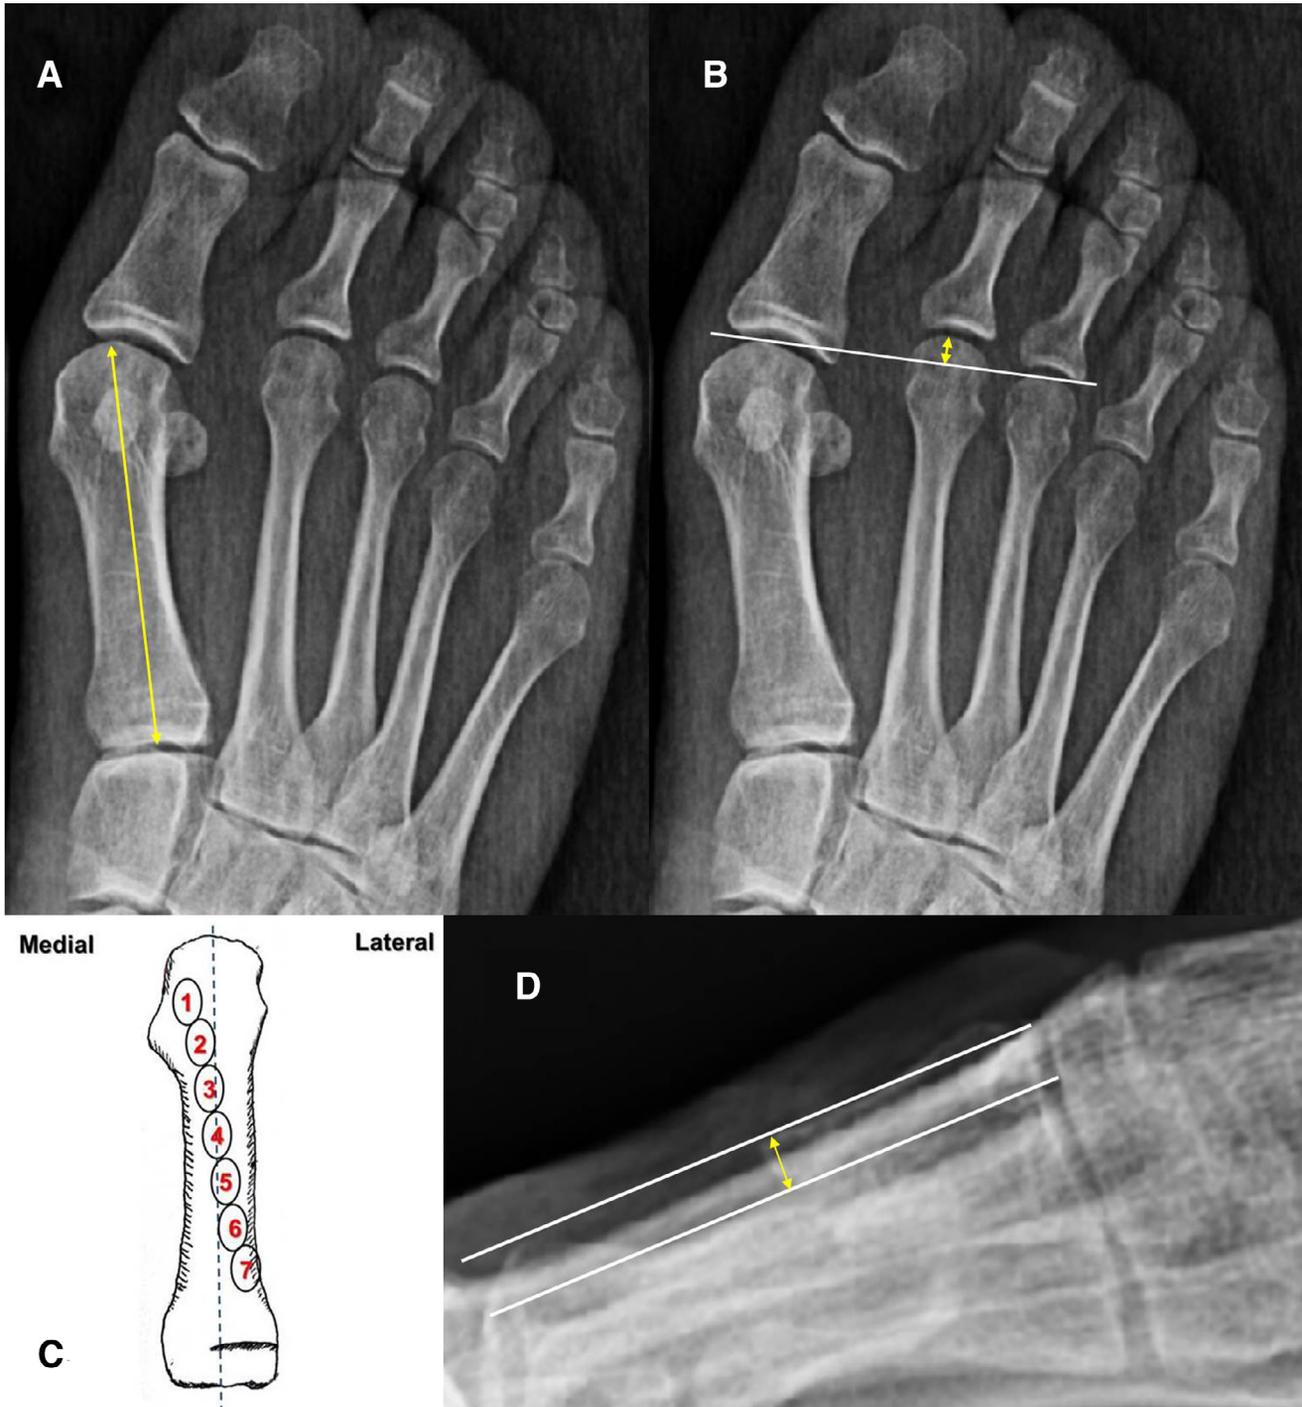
The length of the first metatarsal was defined as the longitudinal distance between the center of the first metatarsal base and the first metatarsal head (A). The relative length of the second metatarsal was defined as the perpendicular distance from the apex of the second metatarsal head to the line drawn between the apex of the first and third metatarsals (B). Hardy and Clapham's medial sesamoid location numbering system (C) was based on the relationship to the longitudinal midline of the first metatarsal bone. Plantar offset was measured to determine dorsal or plantar migration of the distal fragment using standing lateral radiographs of the foot postoperatively (D).
